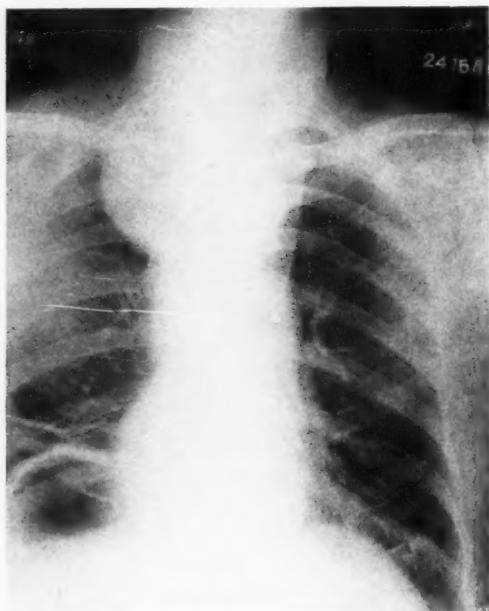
Case 241555. Aneurysm. Clinical findings: Anginal and boring pain; pressure symptoms; positive history of lues and positive Wassermann; expansile pulsating tumor; diastolic shock; exaggerated aortic second sound, diastolic predominance. x-Ray shadow of pulsating expansile tumor, associated with circulatory mechanism.
